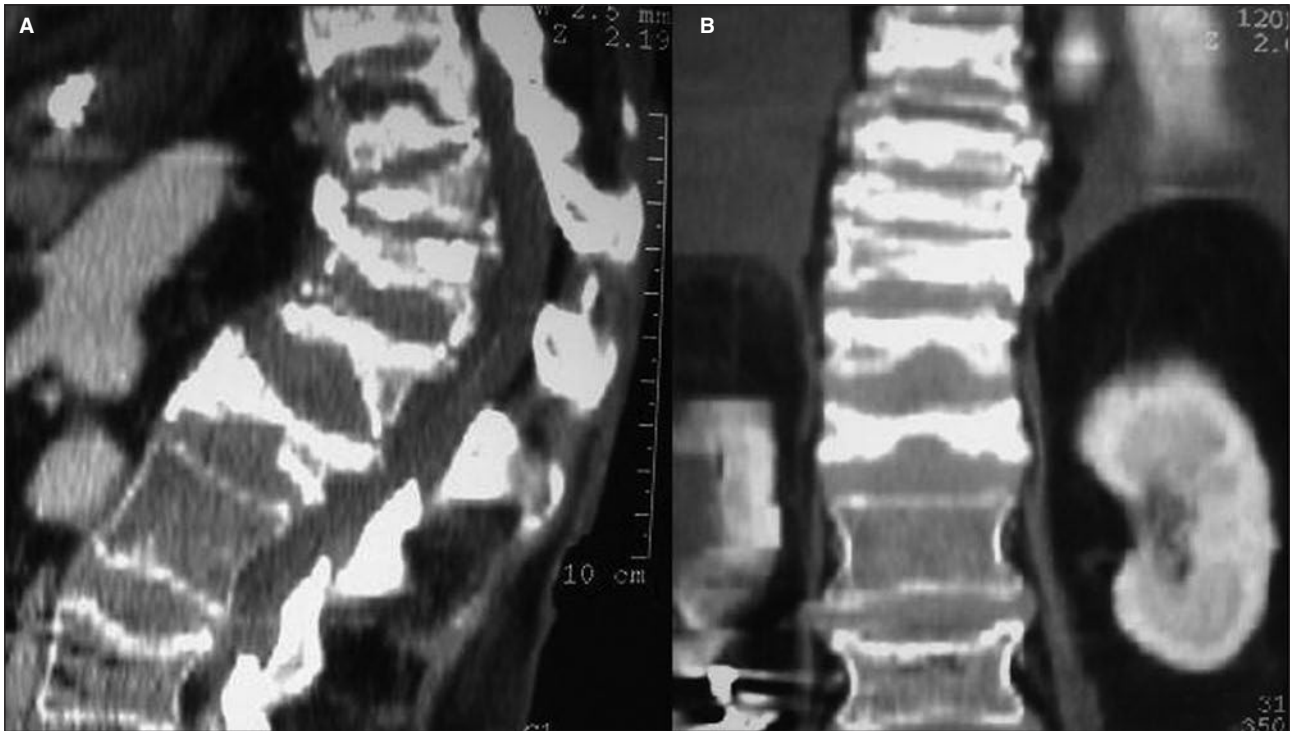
Computed tomography scan of the lumbar spine. Panel A: Sagittal view of lumbar spine. Panel B: Coronal view of lumbar spine.
